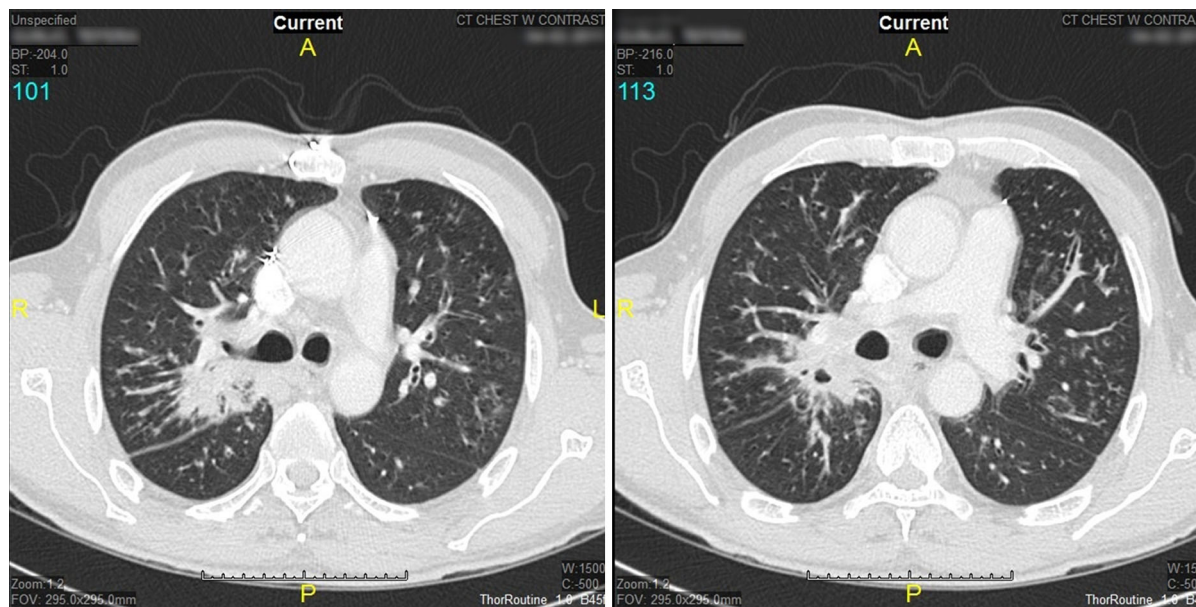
Computed tomography (CT) scan of the chest with a right hilar region mass, mucous impaction and bronchiectasis
